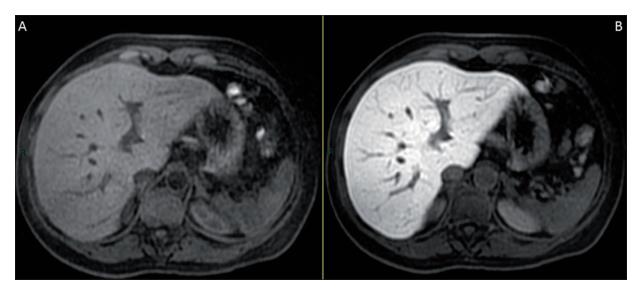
Normal liver. A, Axial T1-weighted fat-suppressed image, obtained before contrast infusion. B, Axial T1-weighted fat-suppressed image obtained in the hepatobiliary phase shows enhancement of the normal liver parenchyma and hypointensity of intrahepatic vessels.
